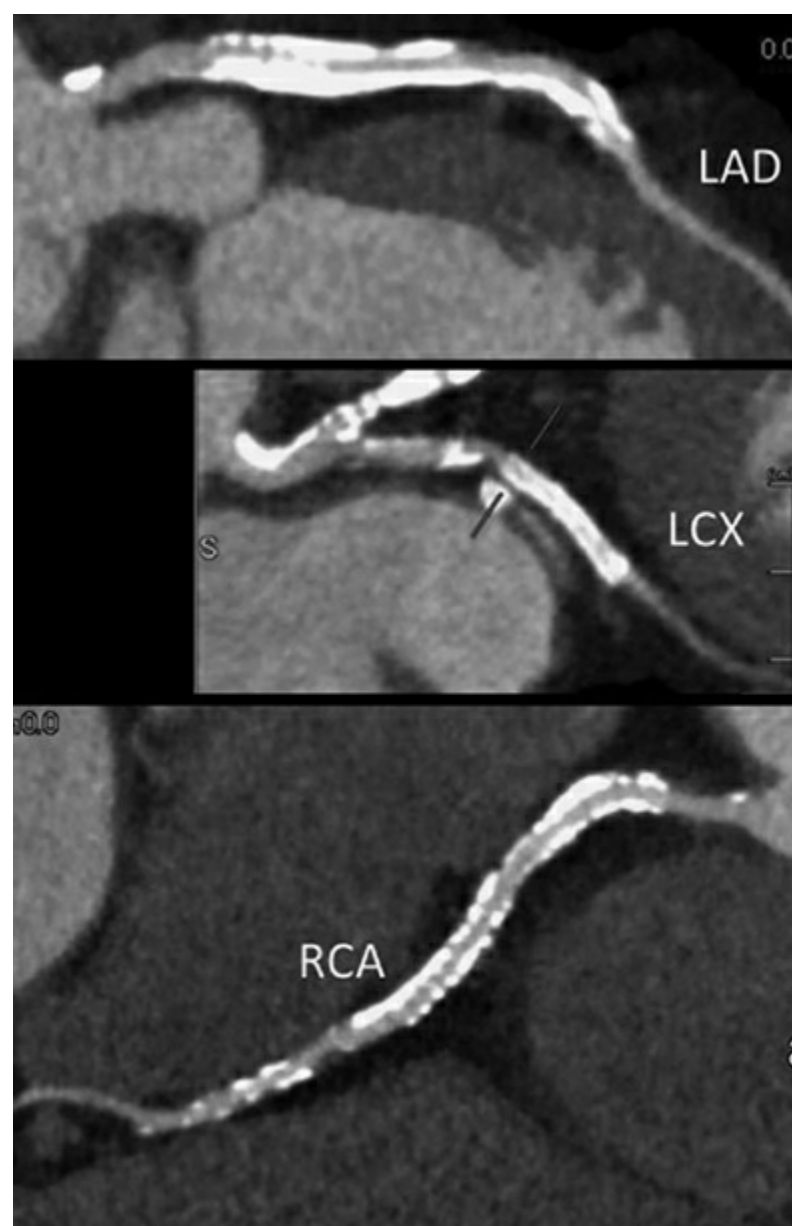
Conventional cardiac computed tomography angiography (CCTA) for evaluation of all three coronary artery vessels. LAD, left anterior descending (artery); LCX, left circumflex artery; and RCA, right coronary artery.
